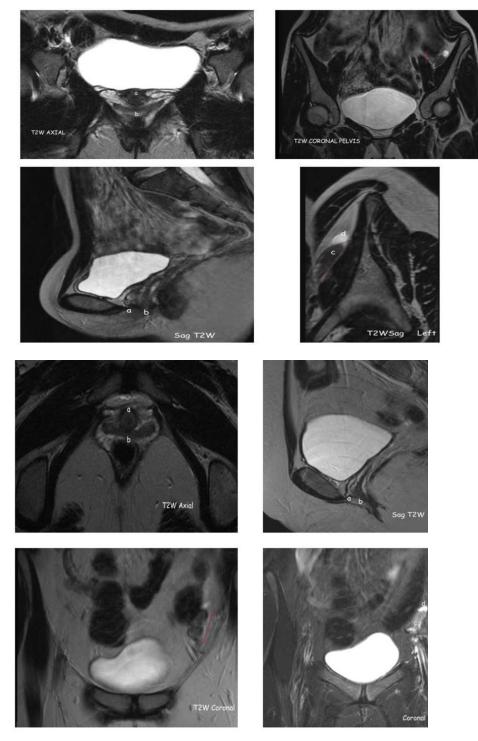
MRI: A 20-year-old female with CAIS syndrome. The axial and sagittal T2-weighted images show present of flattened lower vagina (b) and urethra (a). An axial and sagittal T2weighted images of the lower abdomen and pelvis revealed left testis along the left inguinal region. The parenchyma shows heterogeneous low signal intensity(c) with paratesticular cyst (d).Testis measures 0.71 x 1.3(AP) x 2.0(wt) x 3.6(Ht) cm=6.55cm<sup>2</sup> The cyst measures 1.3 x 1.0cm. 209x297mm (200 x 200 DPI)
